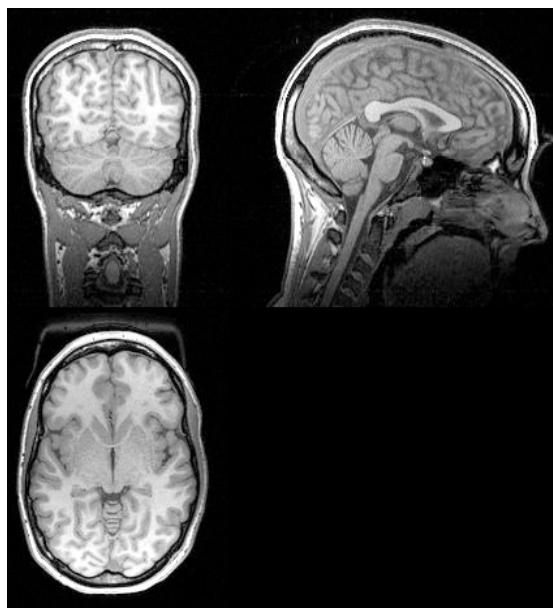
Example of (static) MRI anatomical image. Clockwise from top left: coronal slice (viewed from back of brain), sagittal slice (viewed from left side), and axial slice (viewed from top).
